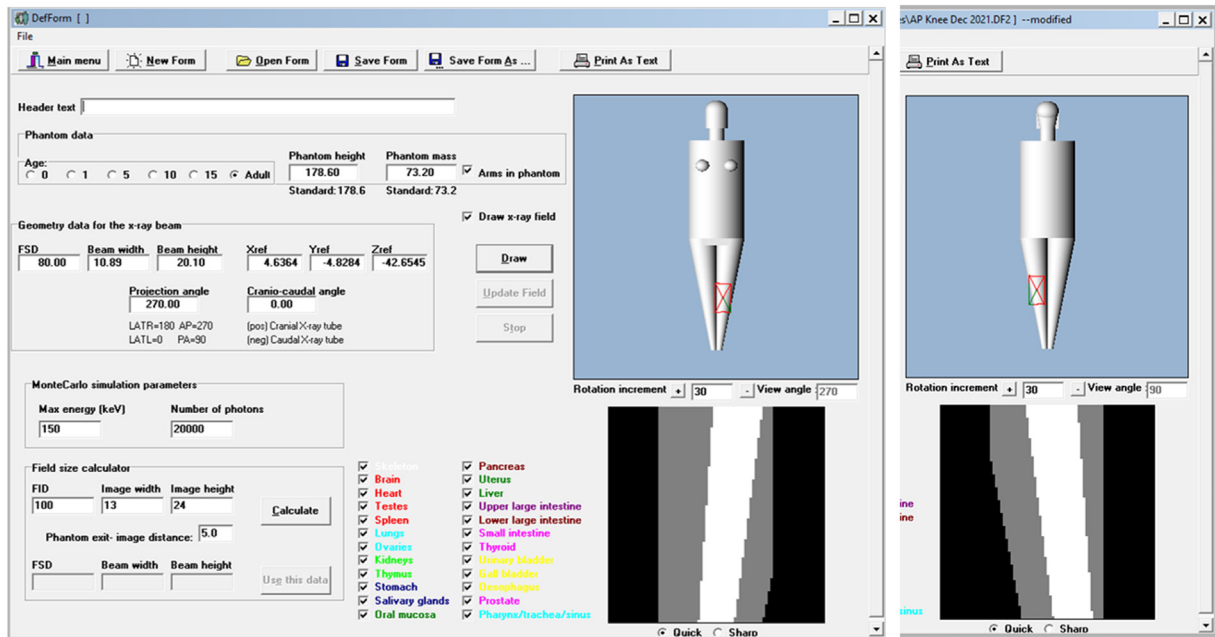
Monte Carlo modelling using PCXMC²⁶ software of an AP (left image) and PA (right image) adult knee X-ray.
